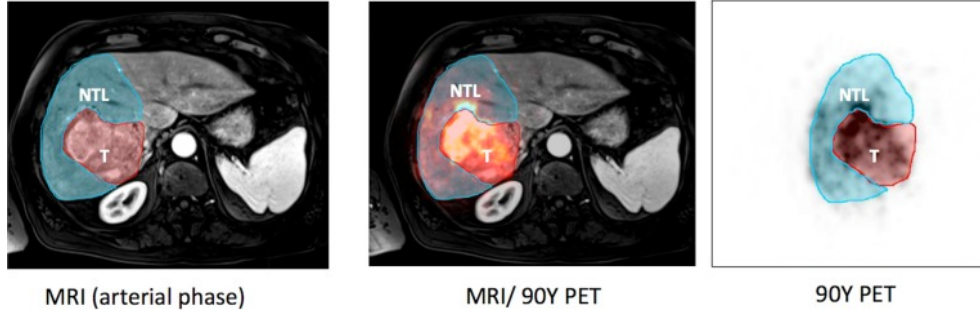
Example of a patient with a large hepatocellular carcinoma shown on MRI (left panel). T represents the tumor and NTL, the normal targeted liver. The liver distribution of ^{90}Y -microspheres is assessed by ^{90}Y PET (right panel), fused with MRI (middle panel).
